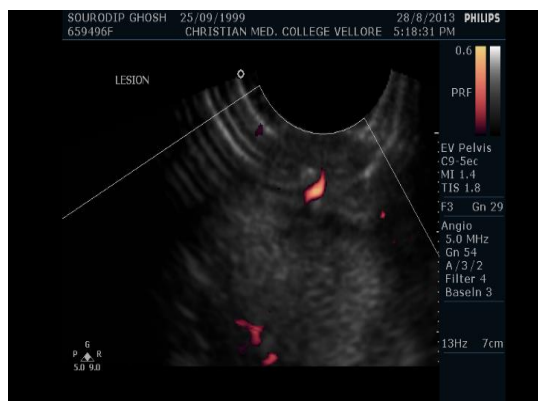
Color doppler showing internal vascularity
